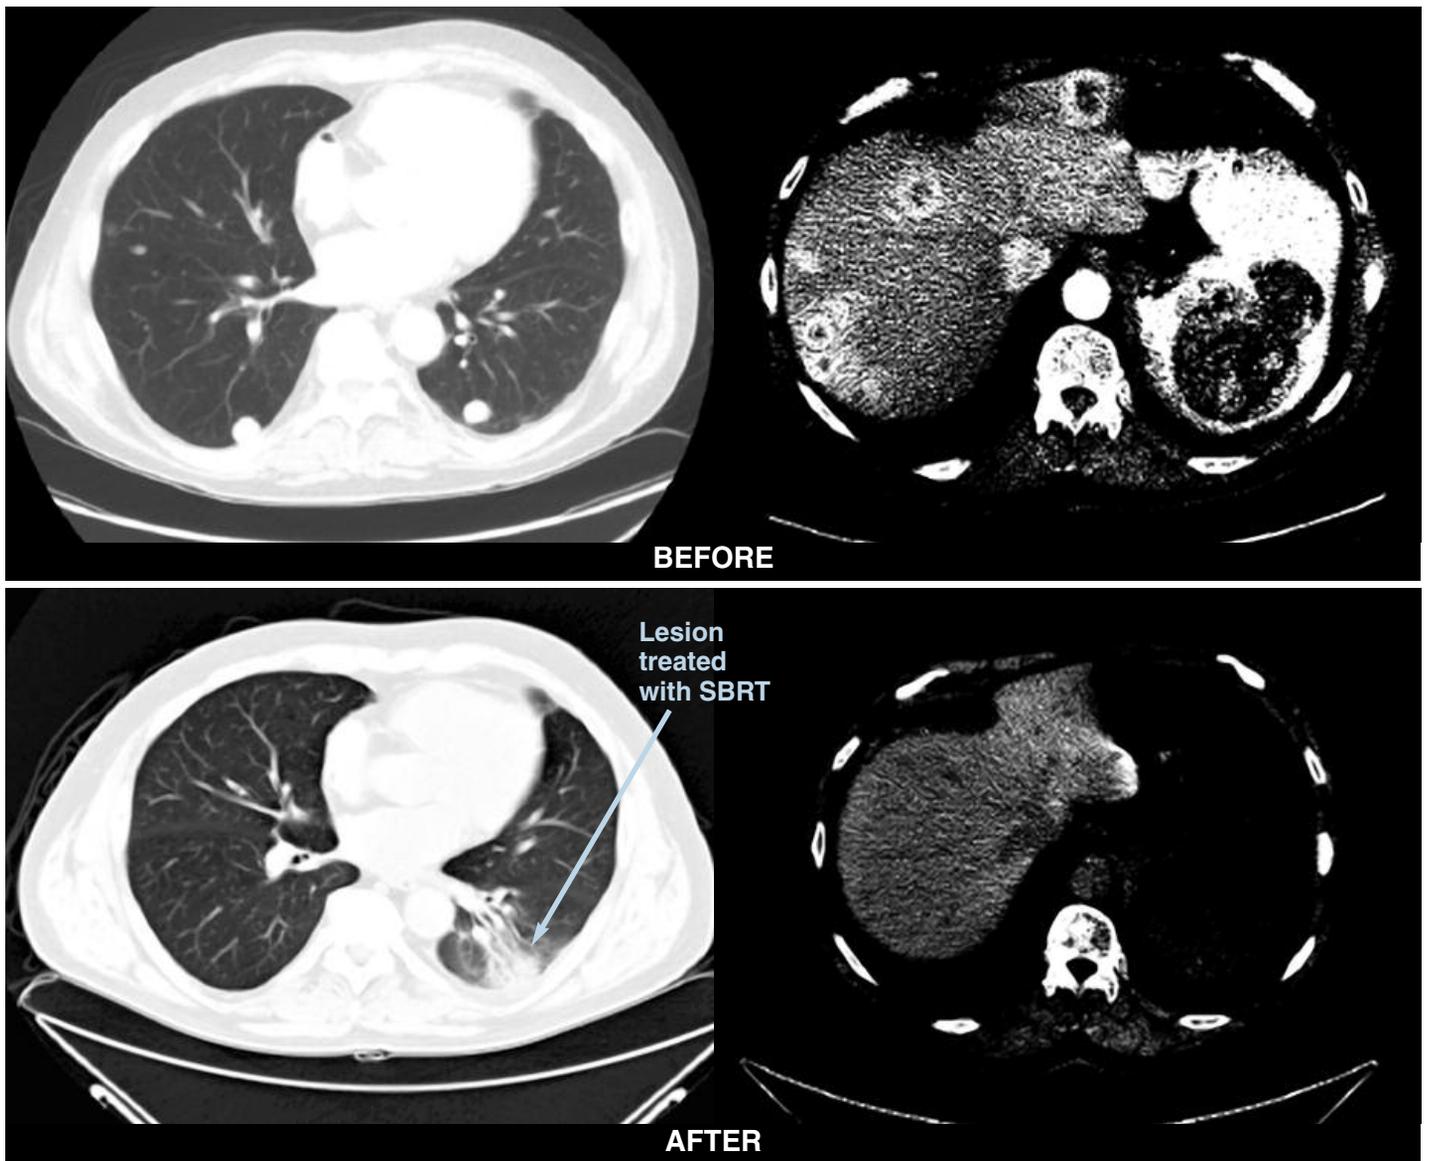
This subject has renal cancer metastatic to lung and liver. The lesion treated with SBRT is indicated. All hepatic and pulmonary metastases regressed and the patient has no FDG-avid lesions on PET imaging now greater than 5 years after therapy. The fibrotic changes in the lung after SBRT are typical.
